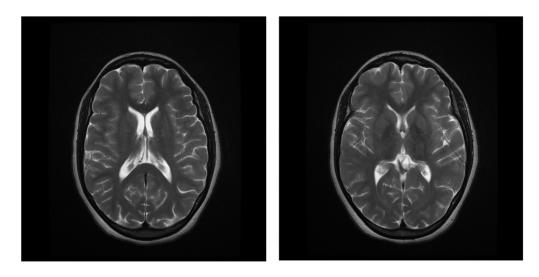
MRI brain scans of an adult patient with Alpha-Mannosidosis. The MRI scans depicted in the figures show subtle diffuse supratentorial deep white matter changes, as well as cerebellar atrophy within the brain of a 32-year-old untreated patient with AM, who has mild learning difficulties and new-onset psychosis.
